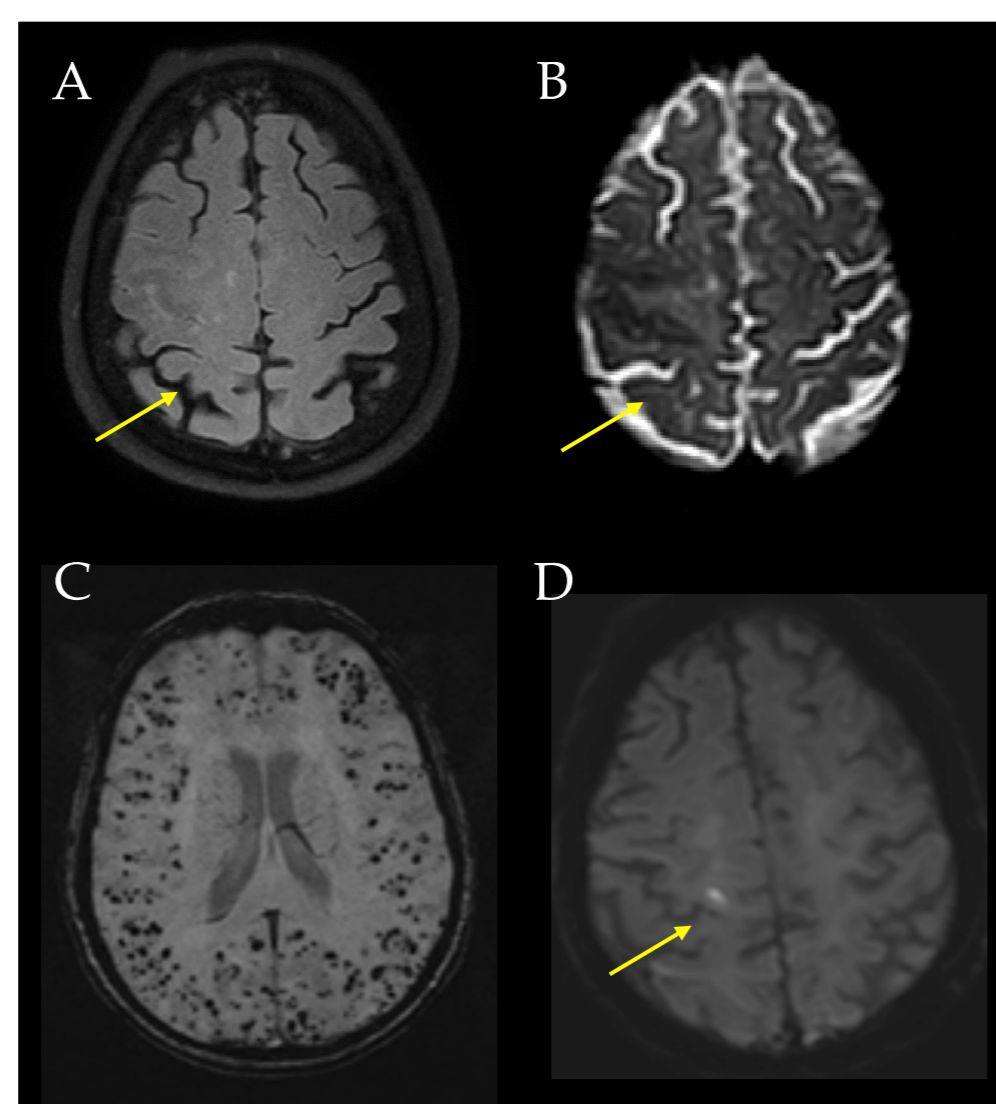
MRI imaging (axial slices) of typical CAA elements. cSAH on FLAIR image (A) as sulcal hyperintensity (arrow); focal cSS on SWI image (B) visible as curvilinear low signal intensity (bilinear 'track-like' appearance) on cortical sulci (arrow). SWI image (C) reveals multiple lobar microbleeds as round low signal spots. Small cortical acute ischaemic lesion on DWI (D, arrow)
